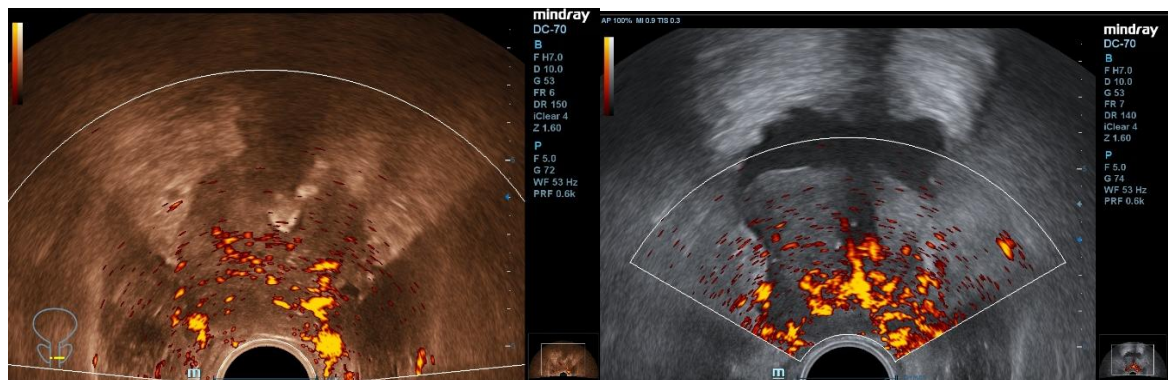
Prostate cancer (PCa). Transrectal ultrasound (TRUS) in the power Doppler imaging mode.
